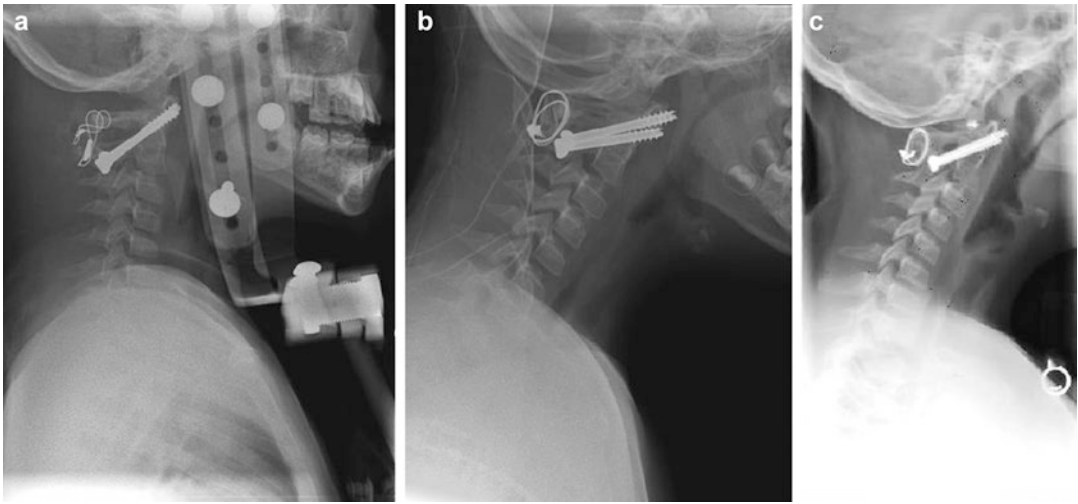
(a) Postoperative radiograph of a 5-year-old child with Down syndrome with C1-C2 instability who developed a deep wound infection after instrumented spinal arthrodesis and later developed pseudarthrosis requiring
